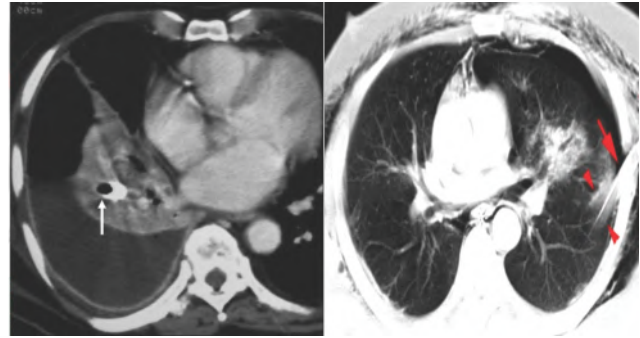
A. Contrast-enhanced axial CT image of the same patient as figure 6 demonstrates the tip of the intercostal drainage tube (arrow) within the lung. B. CT demonstrating chest tube (arrow) penetrating lung parenchyma with surrounding intraparenchymal hematoma (arrow heads), Pneumothorax (yellow arrow), S/C emphysema (green arrow head)
